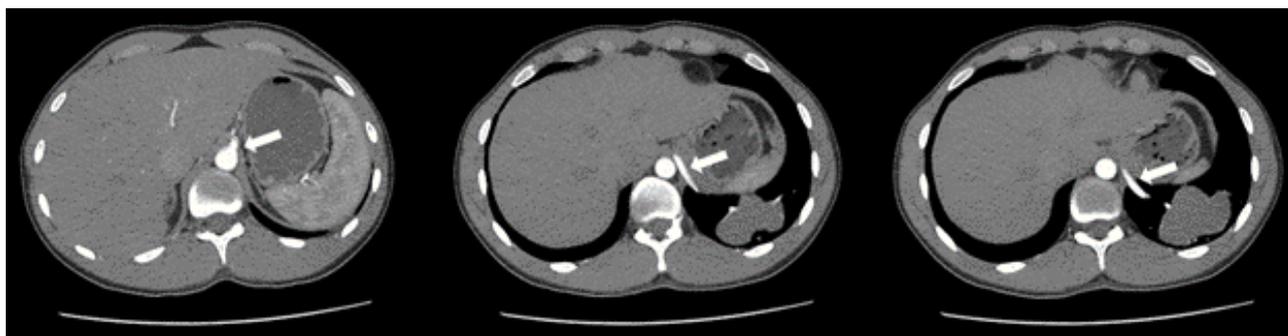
CT angiography confirmed that the affected lesion was supplied by the coeliac trunk (arrows). Imaging highly suggests of intralobar sequestration.
